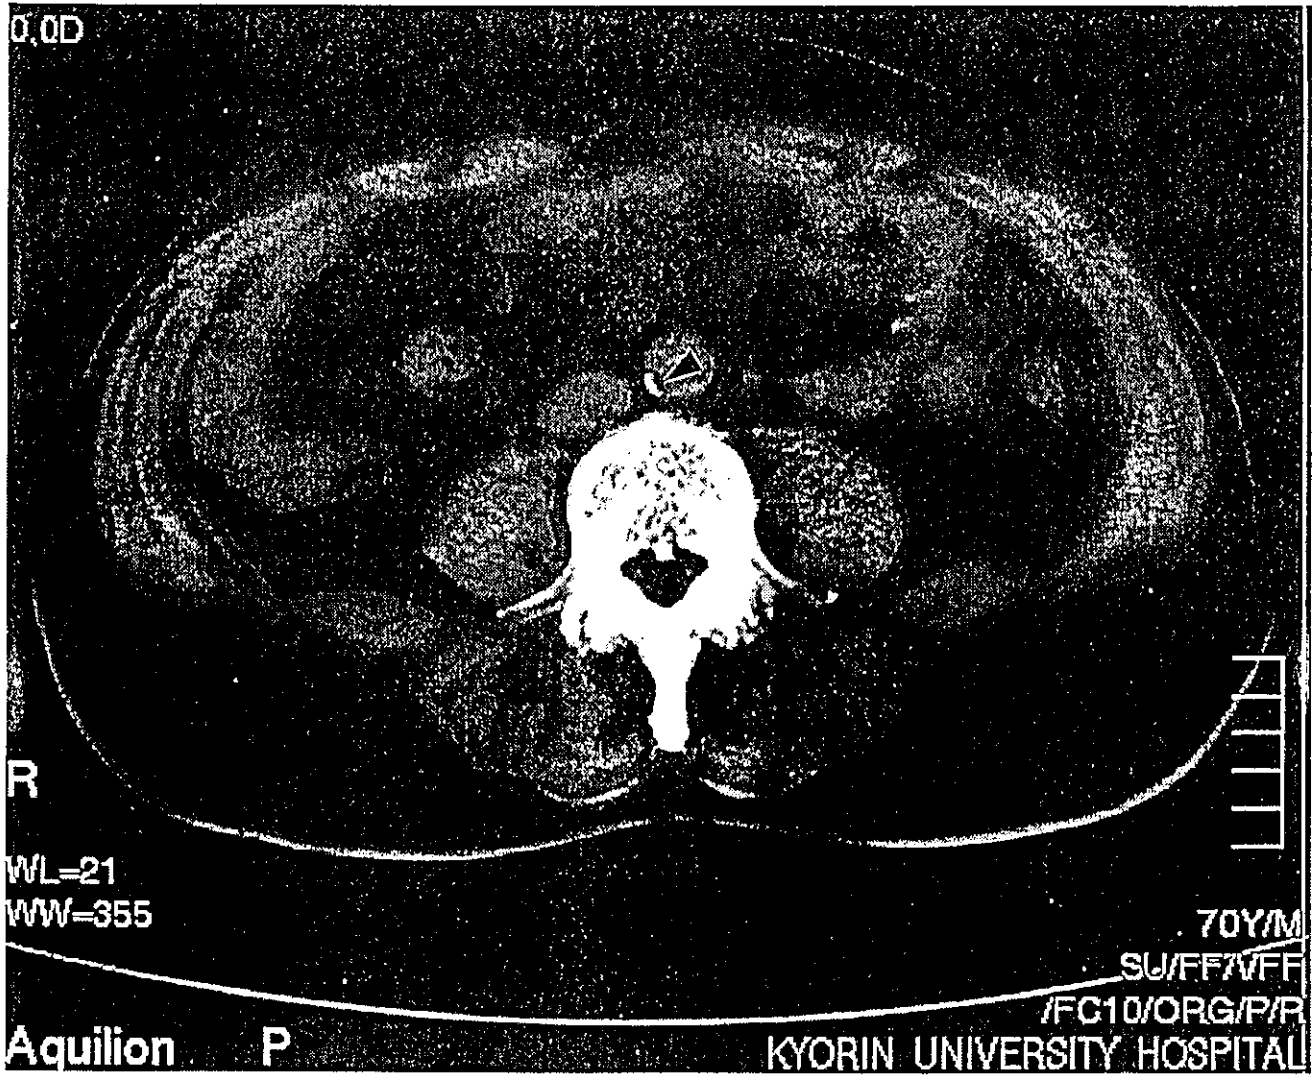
Abdominal plain computed tomographic image at the umbilical level showing that subcutaneous fat is predominant. The arrowhead indicates calcification of the abdominal aorta.
